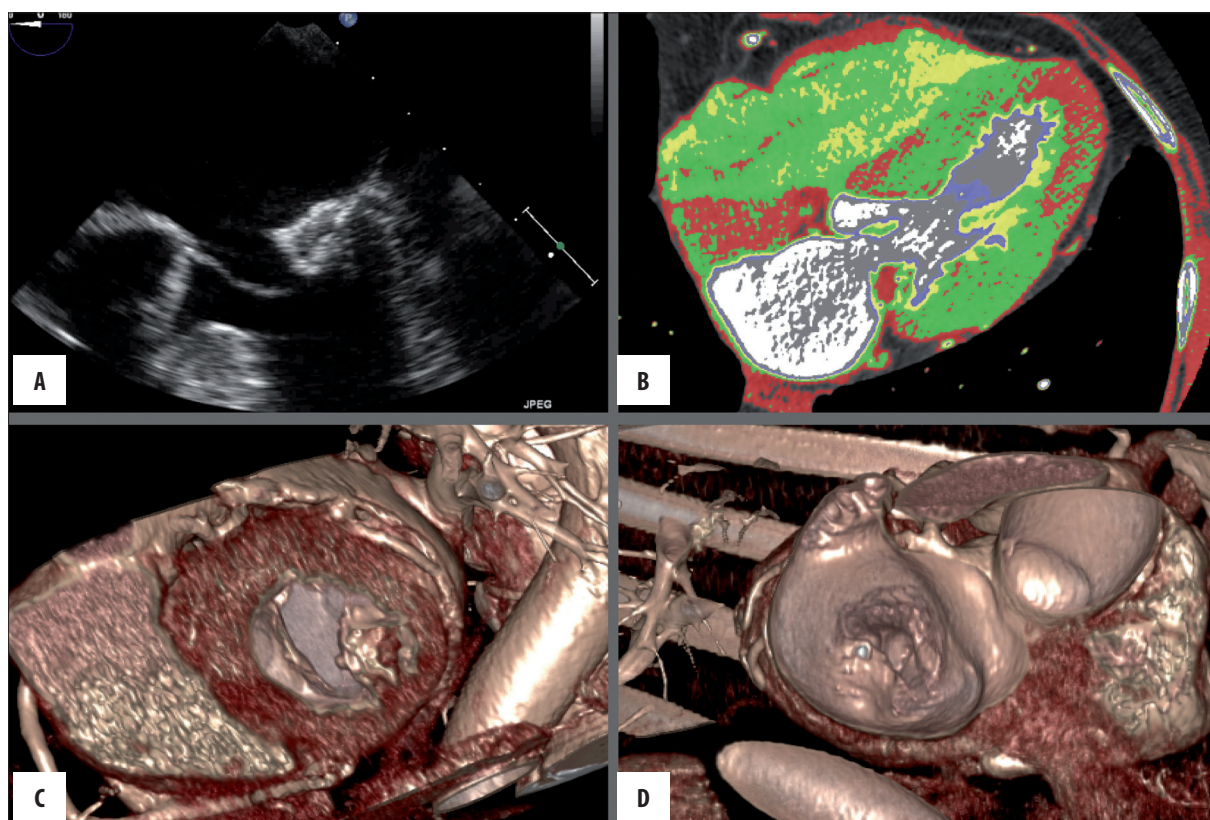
Caseous mitral annular calcification: (A) Transesophageal echocardiography, (B) computed tomography, (C, D) computed tomography – 3D reconstruction.
